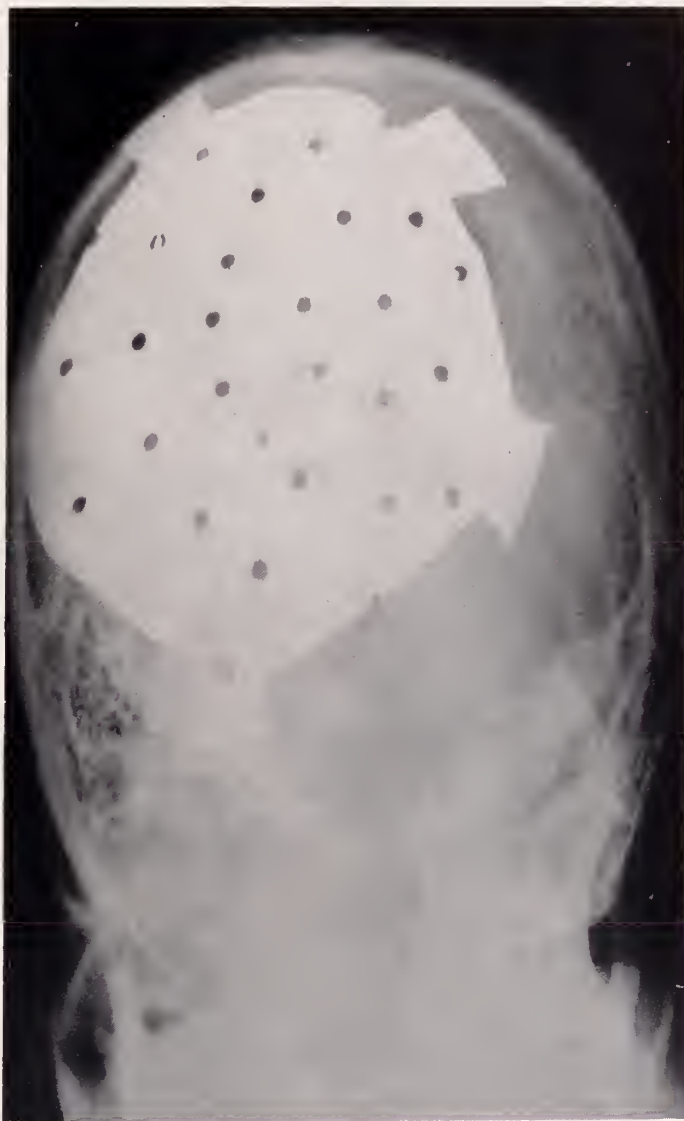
X-ray film of skull showing defect and tantalum repair
